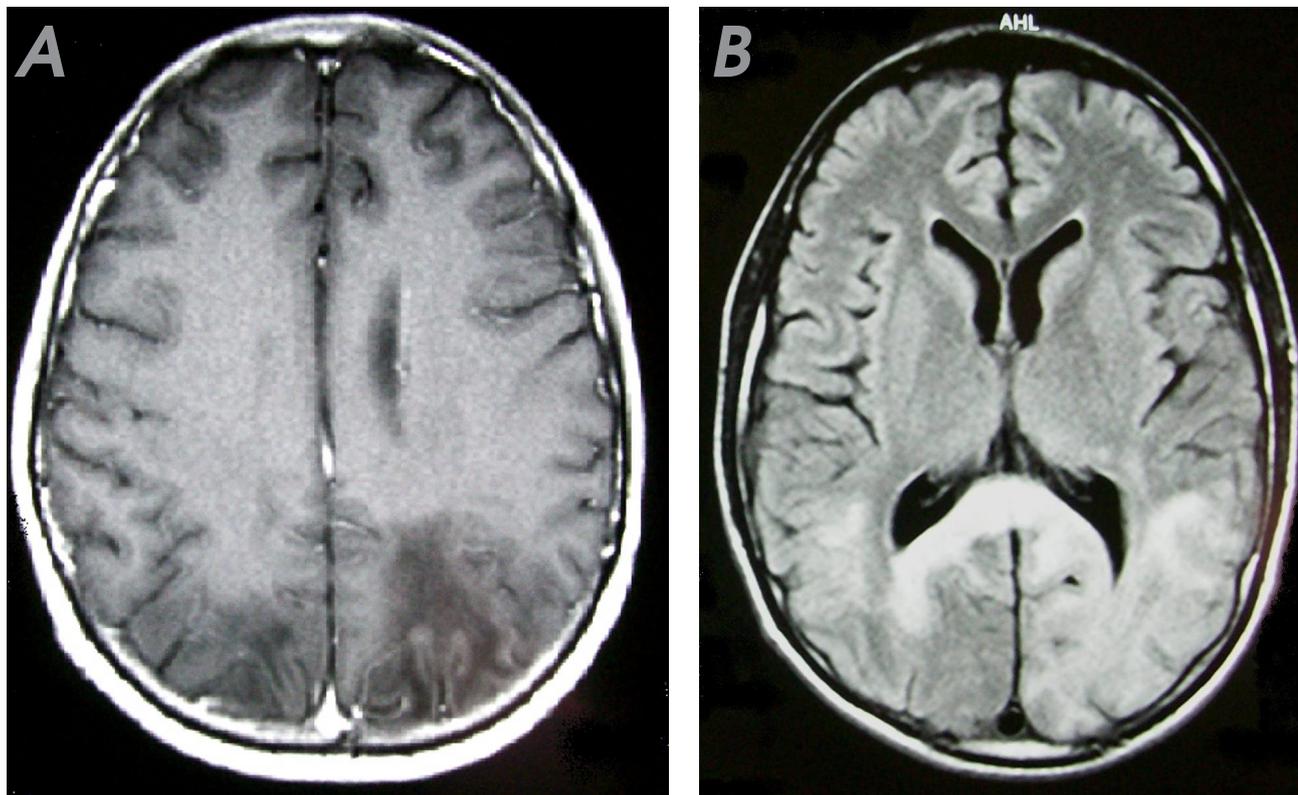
A- lesions with hypointensity on T1-weighted image in subcortical white matter at bilateral occipital areas. B- lesions with hyperintensity on T2-weighted image in subcortical white matter at bilateral parietal and temporal areas.
